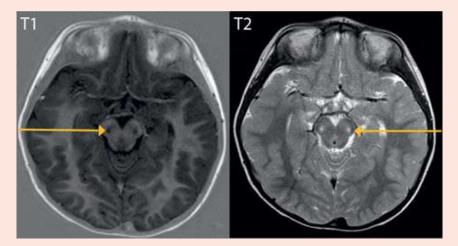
Cranial MRI scan of Archie's optic disc. Yellow arrows indicate the hypointense T1/hyperintense T2 signal change in the substantia nigra of the midbrain.
